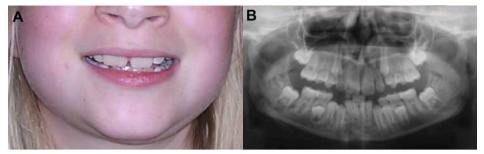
Note macrodontia of upper incisors; (A) the propositus at age 10 years. Also note broad nasal tip and hypoplastic nares; (B) panoramic radiograph at age 10 years.
